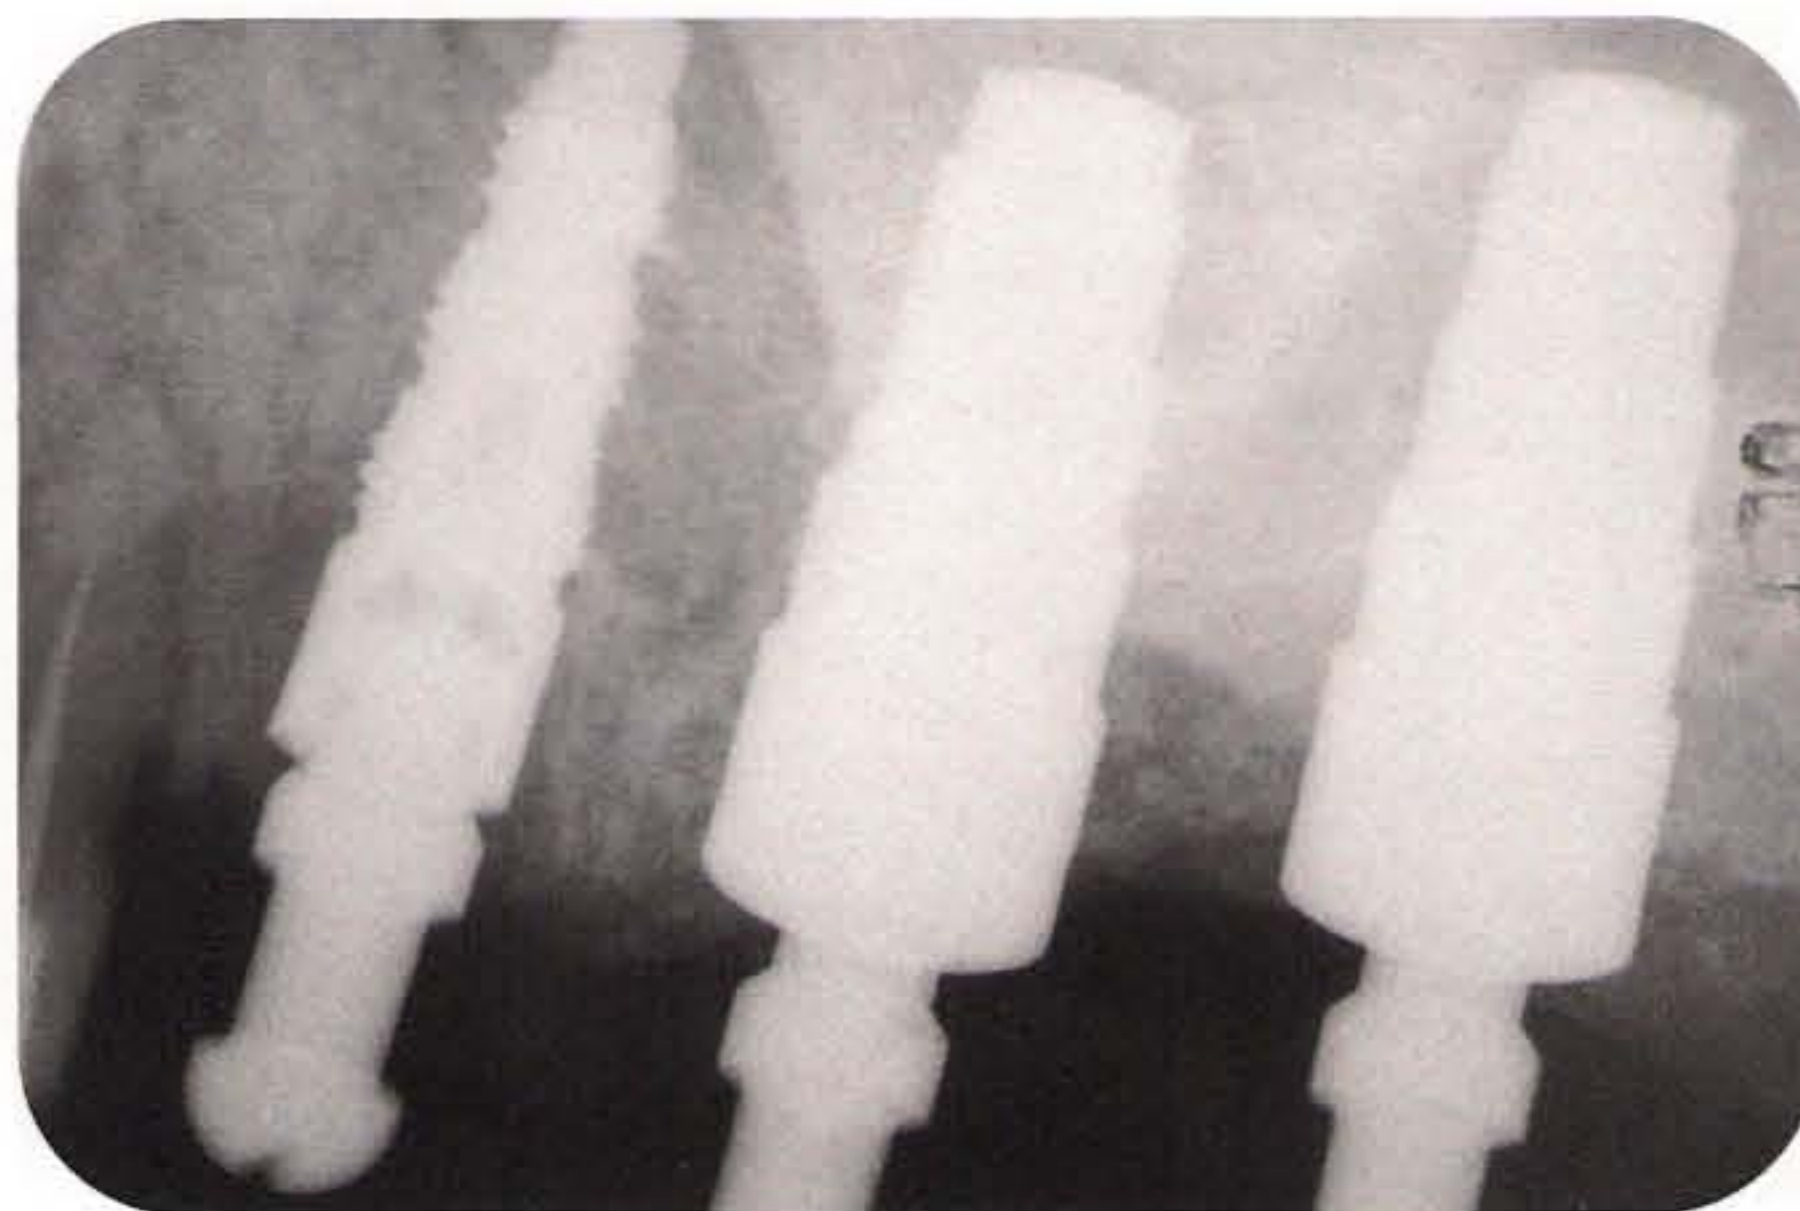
Radiograph to check the correct placement of the implants for the second premolar, first molar, and second molar. Note the correct positioning and dimension of the elevated maxillary sinus, particularly around the molars. The sinus floor has been elevated by 8 mm in the molar area. Localized management of the sinus floor was used.
